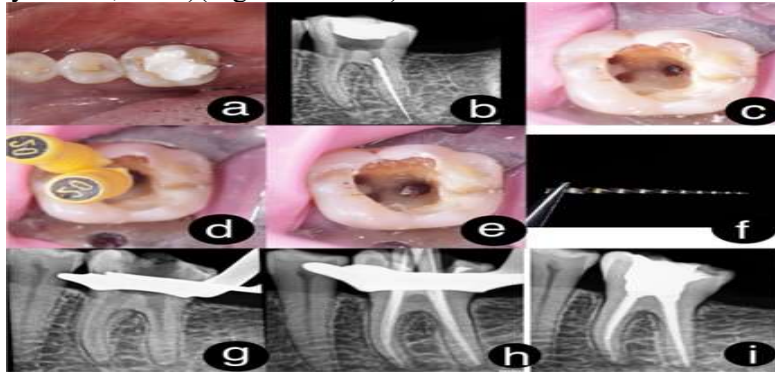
a) Pre operative clinical b) pre operative radiograph c) Creating straight line access c) Dual file braiding using two 20k files e) File popping in the access cavity f) Retrieved file g) Post retrieval radiograph g) Master cone radiograph h) Obturation radiograph
